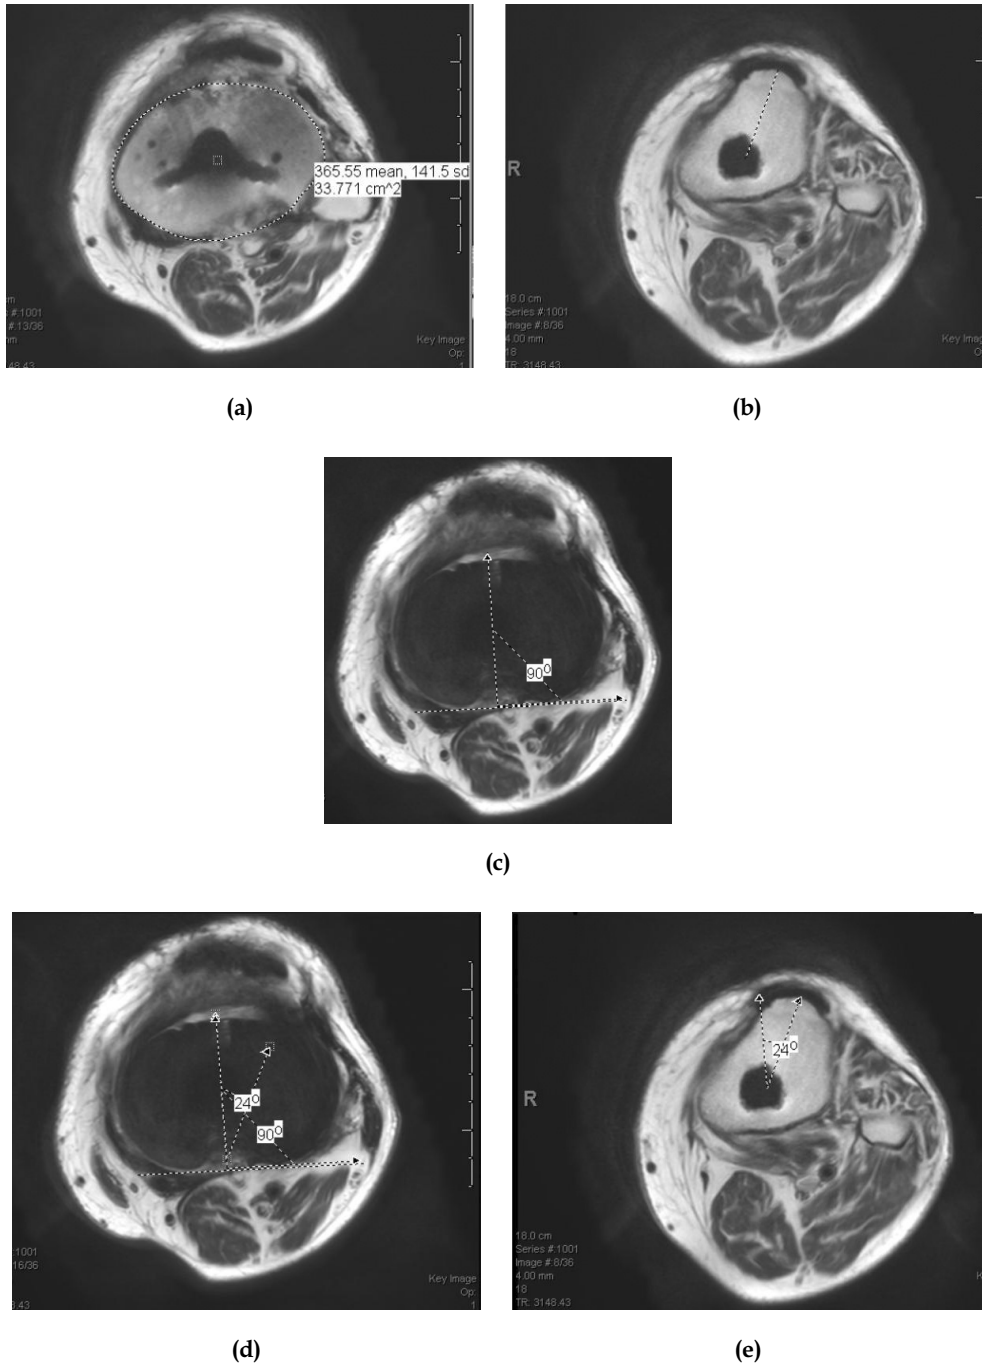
(a) Axial MRI image through the proximal tibial plateau, showing the best-fit circle of the proximal plateau. The center is marked automatically by the computer. (b) Axial image through the tip of the tibial tubercle. The geometric center of the tibial plateau was transposed distally to this image. The tibial tubercle orientation is the line connecting the geometric center of the tibial plateau to the tip of the tibial tubercle. (c) Axial MRI image through the tibial component polyethylene. The tibial component axis is perpendicular to the transverse axis of the tibial component (posterior margin of the component in symmetrical tibial components). (d) Axial image through the tibial component polyethylene. The tibial tubercle orientation is superimposed on the tibial component axis. (e) The rotation of the tibial component is recorded as the angle subtended by the tibial tubercle axis and the tibial component axis.
